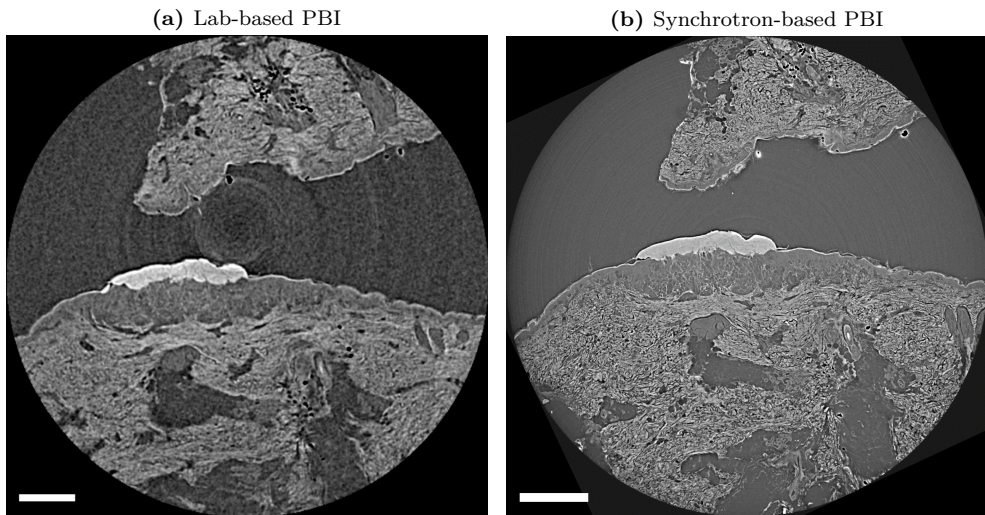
Same area of the melanoma tissue embedded in the paraffin block acquired with (a) a X-ray PBI laboratory setup at the OptImaTo lab (Trieste, Italy), and (b) by means of synchrotron based-XPCT at the SYRMEP beamline, which serves as a comparison. The scalebar is 1 mm. Experimental lab-based XPCT data: 70 kV, 3.57 mA, SSD: 38 cm, SDD: 228 cm, and effective pixel size: 12.5 μm . Experimental synchro-based XPCT data: white beam, average X-ray energy: 21 keV, SDD: 20 cm, and effective pixel size: 2.0 μm .
